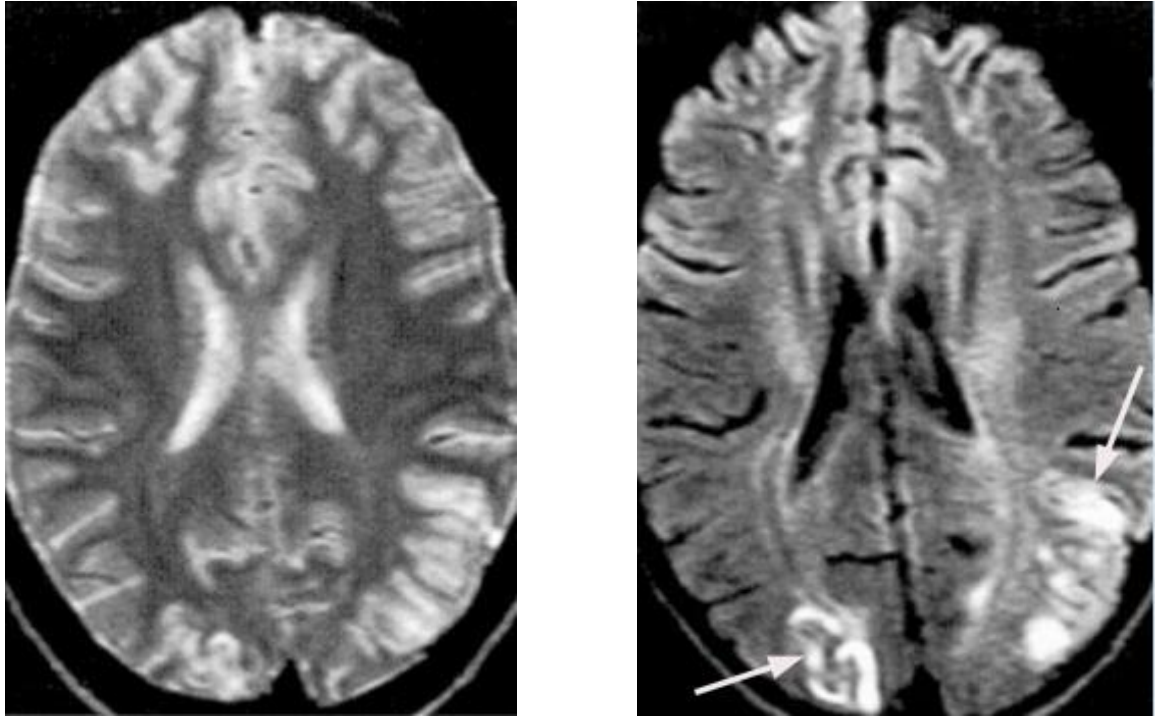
T₂-weighted SE (left) and FLAIR (right) images in cortical infarction (1992). Areas of abnormality are better seen on FLAIR image (arrows).
